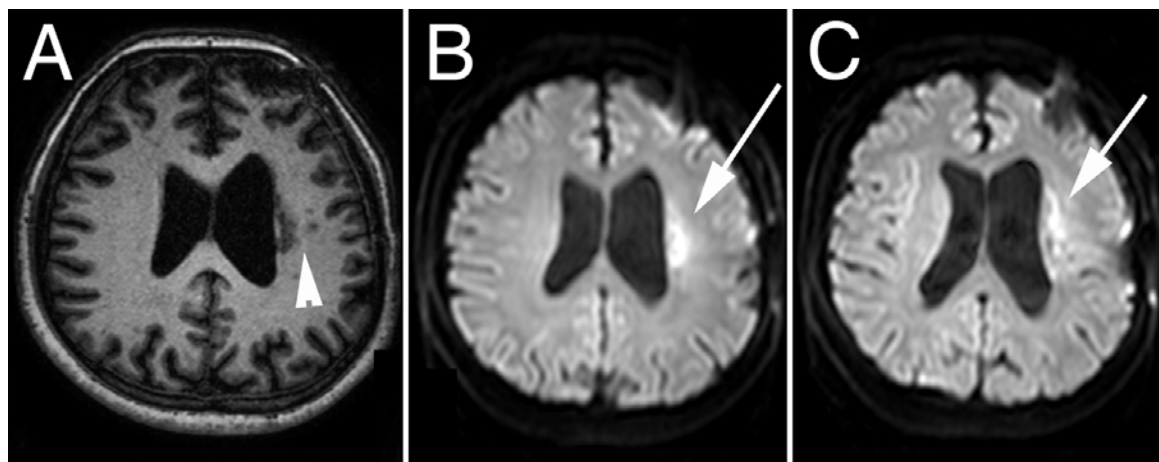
Axial FLAIR image (A) revealing the punctate areas of infarction in the periventricular white matter (arrowhead). The axial diffusion-weighted images (B and C) reveal the punctate areas of infarction (arrows), which were found in the vascular territory of the LSAs.
